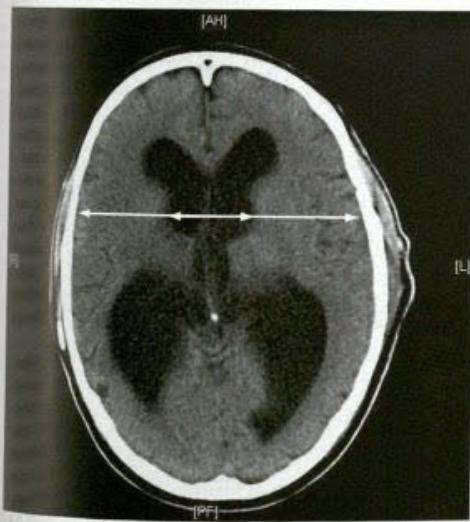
Measurement of ventriculomegaly on axial CT. The bicaudate ratio is 0.35. (Significant ventriculomegaly is a bicaudate ratio of 0.25 or greater.)
